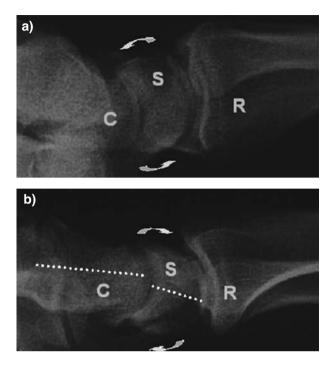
X-ray lateral view: radius (R), lunate (S), capitate (C). Ulnar and radial deviation movements are accompanied by carpal flexion (a) and carpal extension (b), respectively
